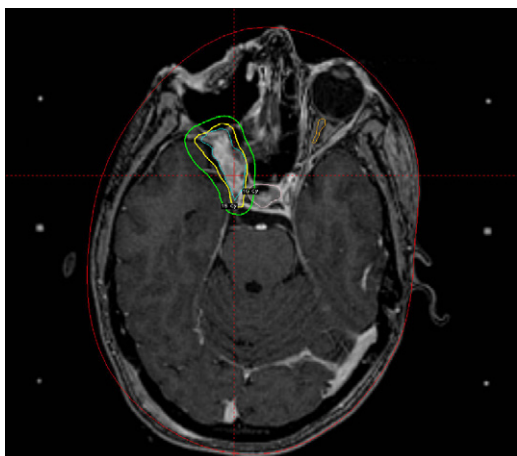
Axial postcontrast T1-weighted MRI with superimposed radiosurgical treatment plan. This female patient with invasive squamous cell carcinoma of the skin of the right eyebrow had been extensively treated with multiple surgeries and external beam radiation. At recurrence she underwent wide local excision of the tumor with orbitectomy. Residual disease in the cavernous sinus was treated with radiosurgery to a dose of 15 Gy at the 50% isodose line. (Courtesy of Department of Neurosurgery, The University of Texas M.D. Anderson Cancer Center; with permission.)
